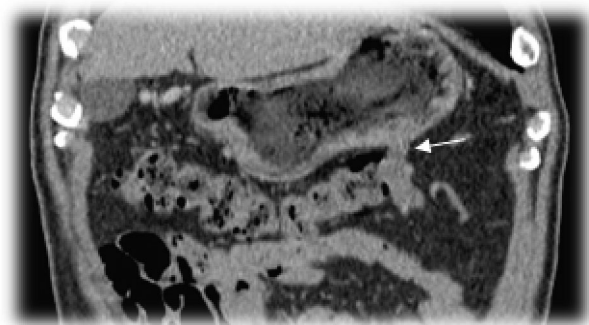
Coronal CT image show a pedicle (arrow): the tumor appeared to be connected with the wall of the gastric body by a pedicle.
